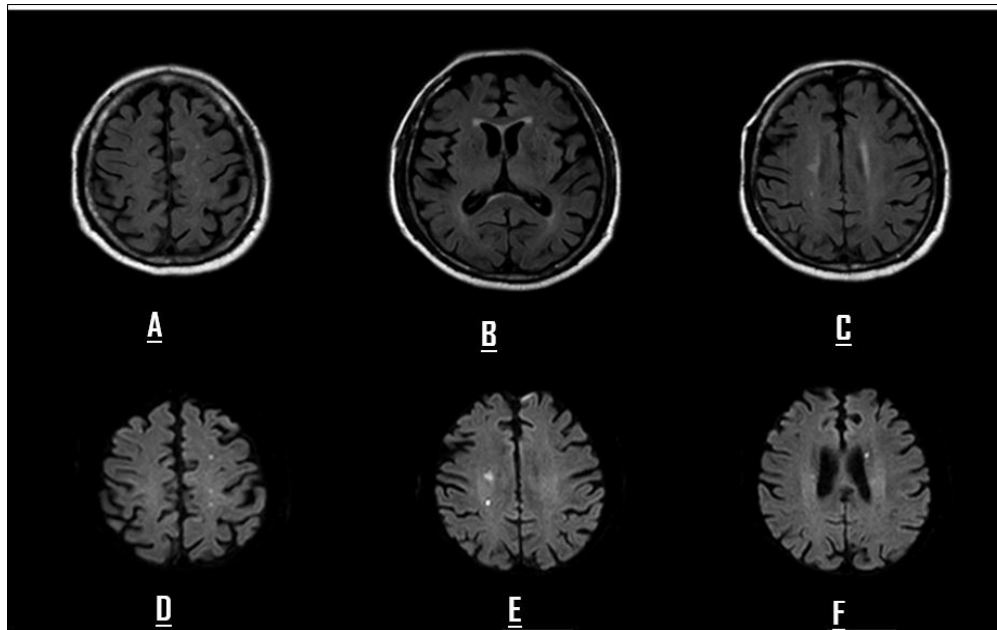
Brain MRI Axial plan FLAIR and DWI . In DWI images bilaterally acute ischemic lesions, on F image acute left caudate nucleus millimetric ischemic lesion.
